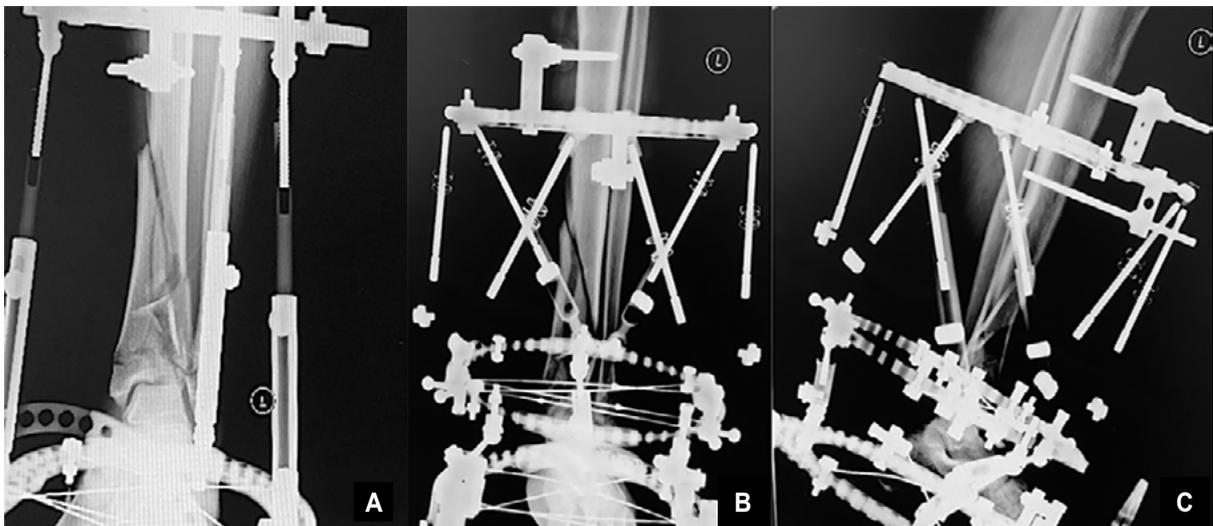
A) Anteroposterior X-ray of a tibial plafond fracture managed with a proximal tibial ring and distal foot plate in a spanning construct. B and C) Anteroposterior and lateral X-ray demonstrating the addition of distal tibial ring with olive and fine wire fixation attached to the distal ring, to aid in articular reduction
